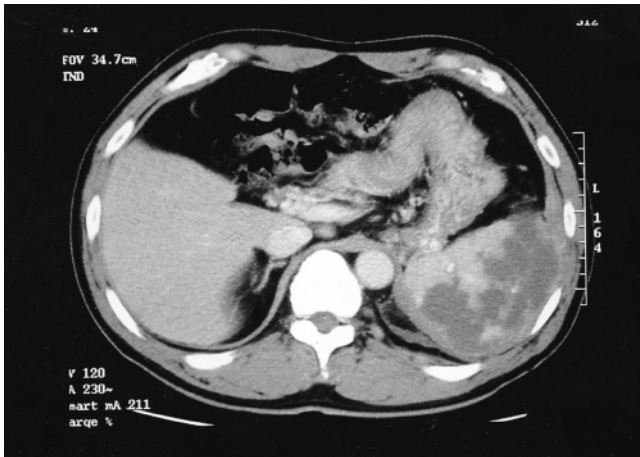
CT scan 2 weeks after splenic arterial embolization; 70% of the spleen volume showed low attenuation, indicating infarction
